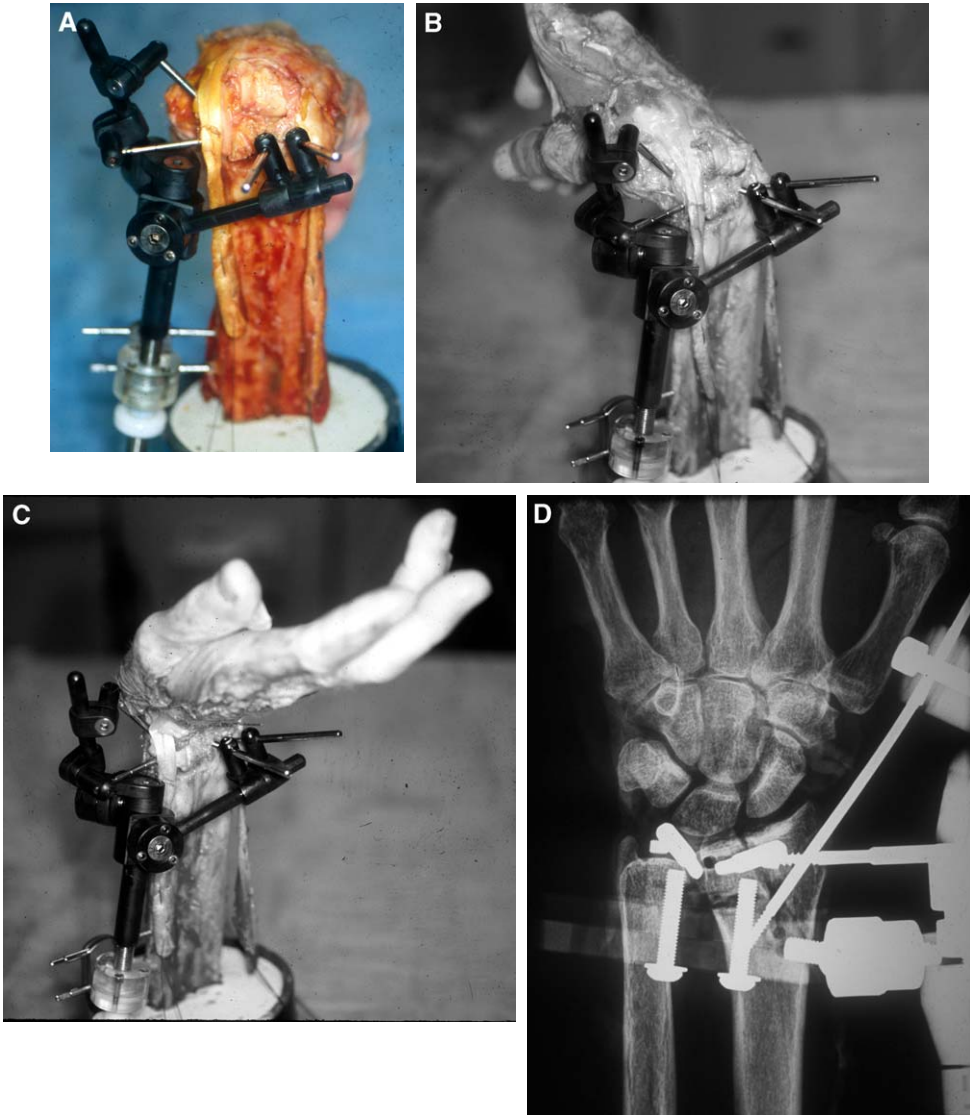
(A) Fragment specific fixator in a three-part fracture with dorsal wedge osteotomy. (B) Demonstration of unrestricted wrist flexion. (C) Demonstration of unrestricted wrist extension. (D) AP radiograph showing pin fixation of a four-part fracture seen through the radiolucent dorsal sidearm of the custom fixator.
